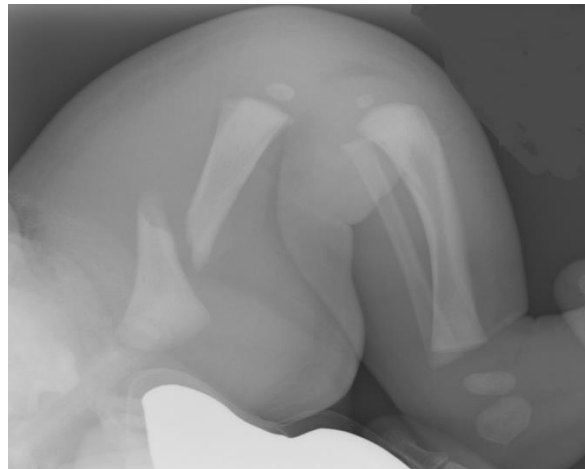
Radiograph shows displacement and angulation/displacing anteriorly compared to the middle and distal segment.
